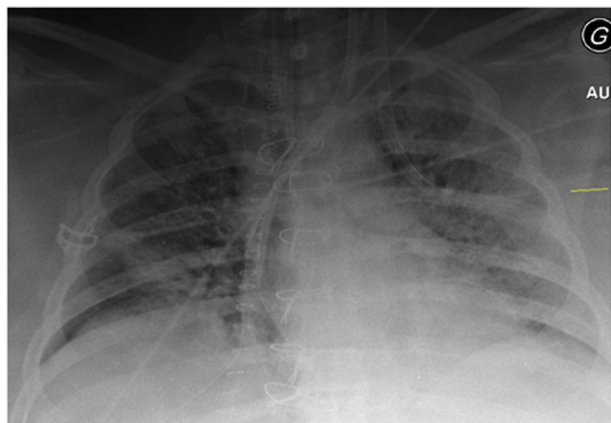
Chest roentgenogram showing bilateral interstitial lung lesions.
